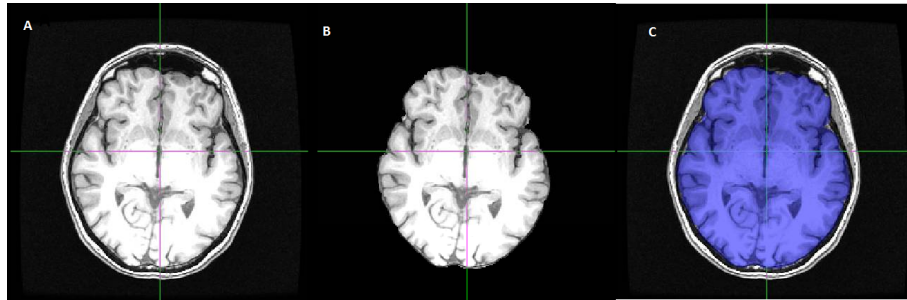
A - Pre-operative T1-MRI; B - T1-MRI after skull stripping using BET and C - Fusion of the images in A and B, where the extracted brain is displayed in blue.
